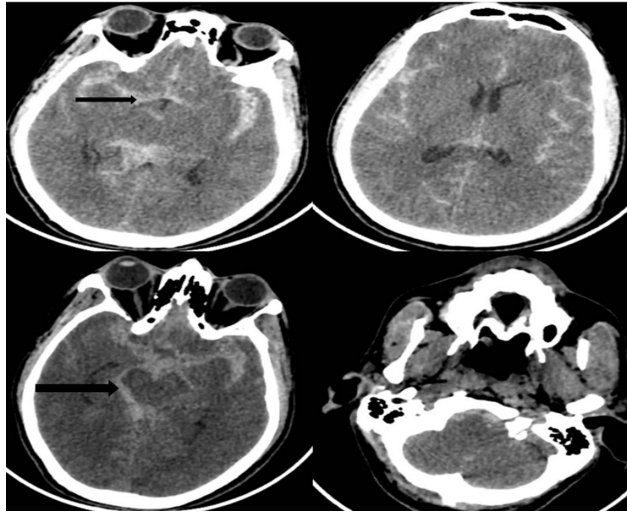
Computed tomography (CT) brain plain suggestive of subarachnoid hemorrhage (SAH) in bilateral sylvian, suprasellar cistern, interhemispheric space with diffuse basal cistern involvement (black arrow). No intraventricular extension shown. SAH is present in left cerebellopontine angle and left cerebellomedullary cistern. No parenchymal involvement shown.
